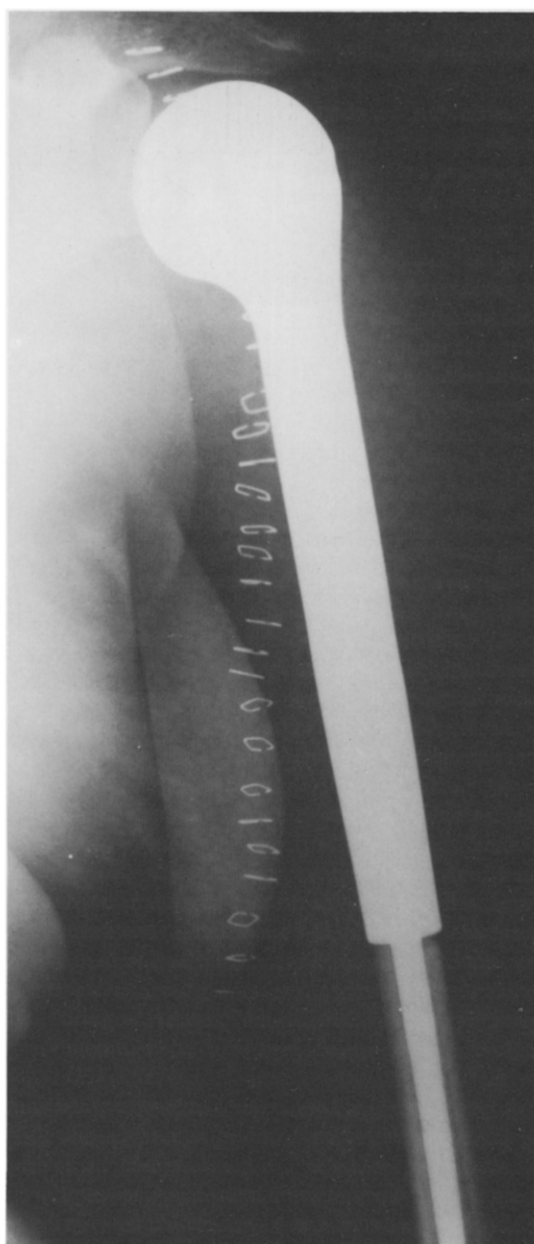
Postoperative X-ray showing the Stanmore humeral endoprosthesis.
